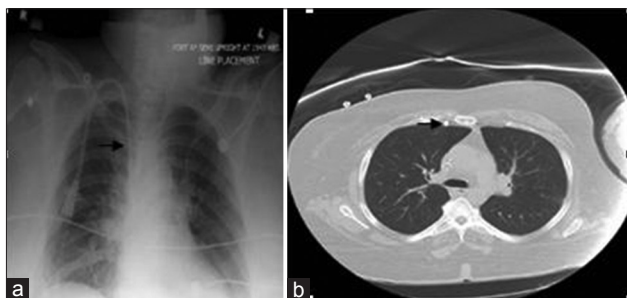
Catheter misplacement to the right internal mammary vein.^[33] (a) Chest X-ray: Anterior-posterior demonstrating what appears to be good position of catheter in the superior vena cava. (b) Computed tomography (axial image): Catheter malposition to the right of the sternum.
